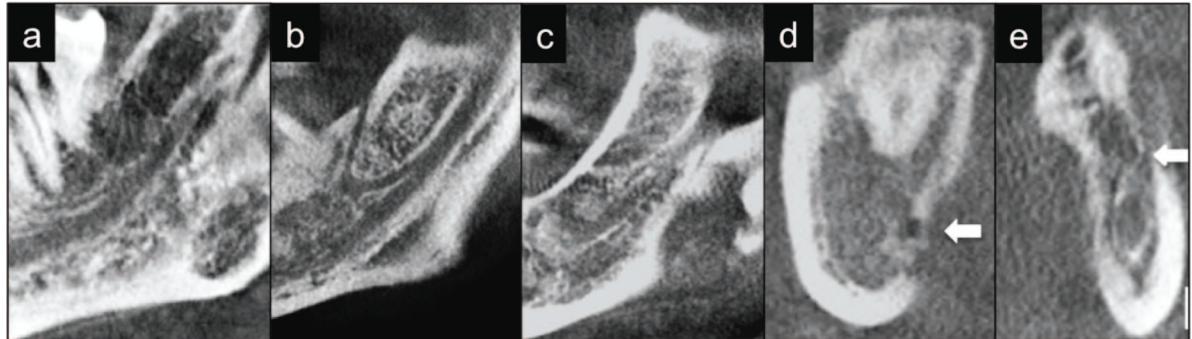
Bifid mandibular canals on CBCT: On sagittal reconstruction: (a) Type I: retromolar canal; (b) Type II: Dental canal; (c) Type III: Forward canal. On cross-sectional images: (d) Type IV: Buccal-lingual canal ; (e) Type V: Superior canal.
